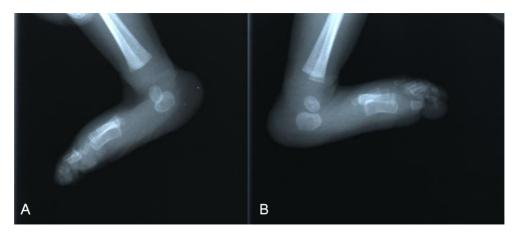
The weight-bearing lateral radiographs of both feet showed a typical vertically oriented talus.
